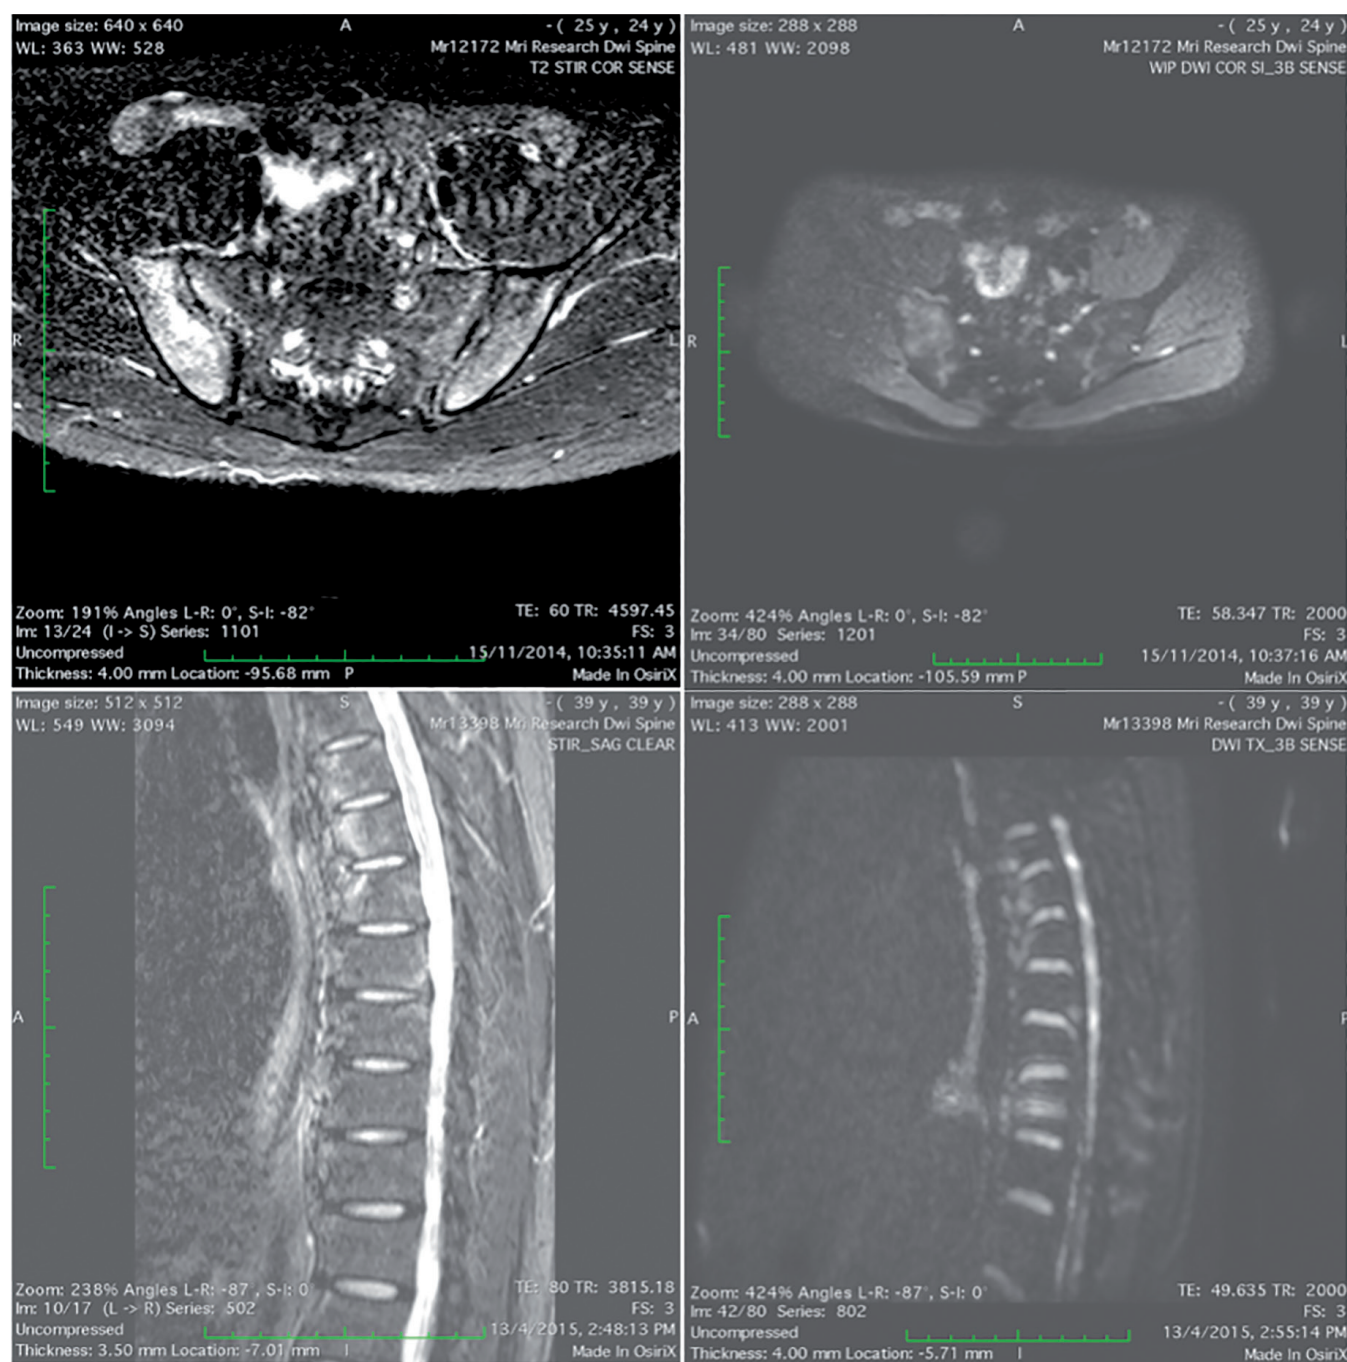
DWI images have poorer resolution. Left upper: STIR SI joints image; right upper: DWI SI joints image. Left lower: STIR spine image; right lower: DWI spine image.
